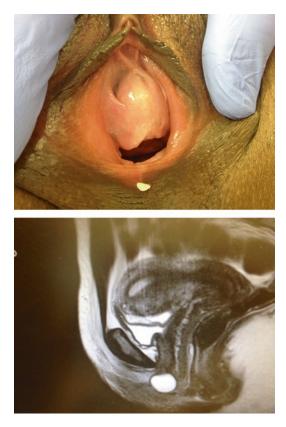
Skene's gland abscess clinically (*top*) and on MRI (*bottom*)
